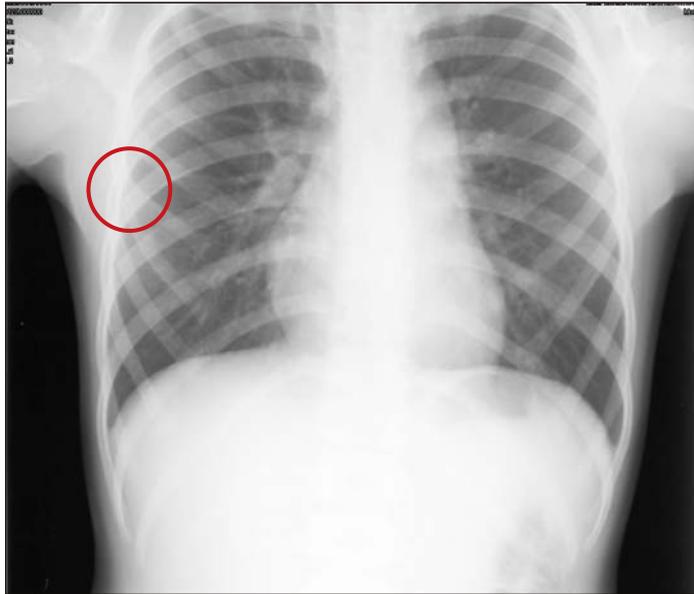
Radiographic film showing a bifid fifth rib on the patient's right side.
